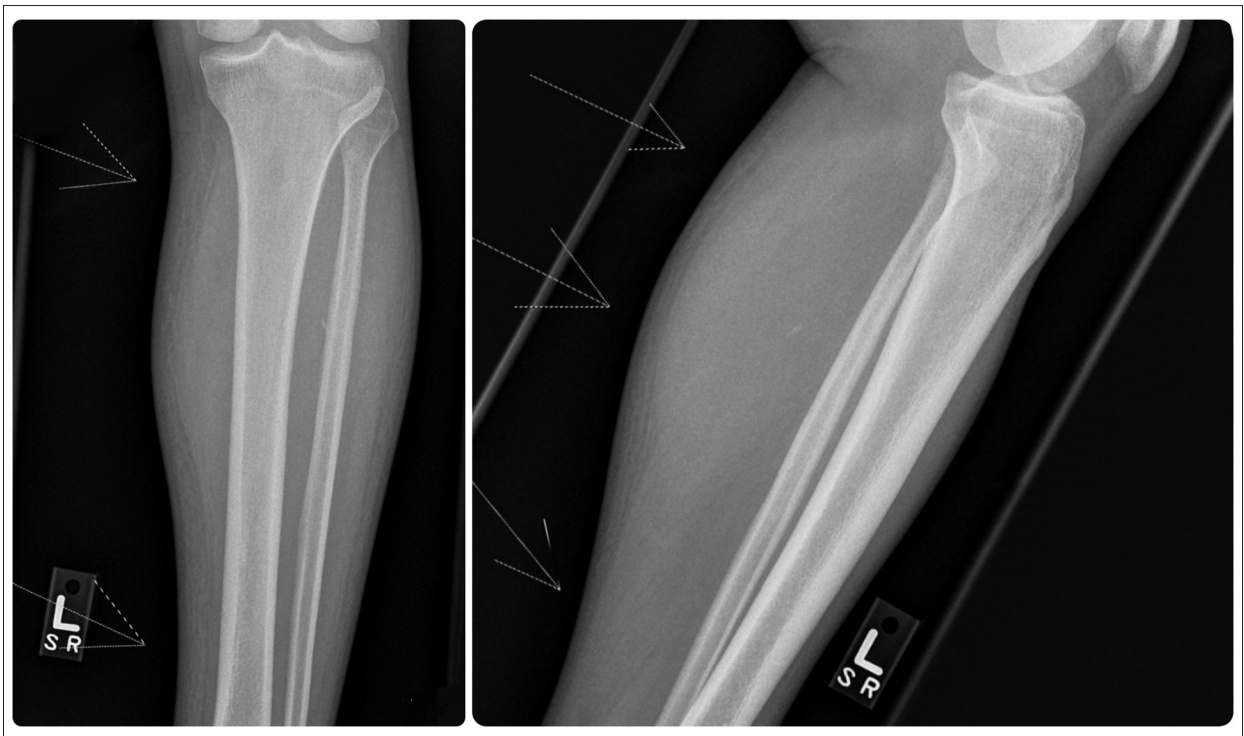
Left AP and lateral tibia fibula X-ray, which demonstrates soft tissue swelling of the calf and a small focus of increased density (white arrows) suggestive of dystrophic soft tissue mineralization.
